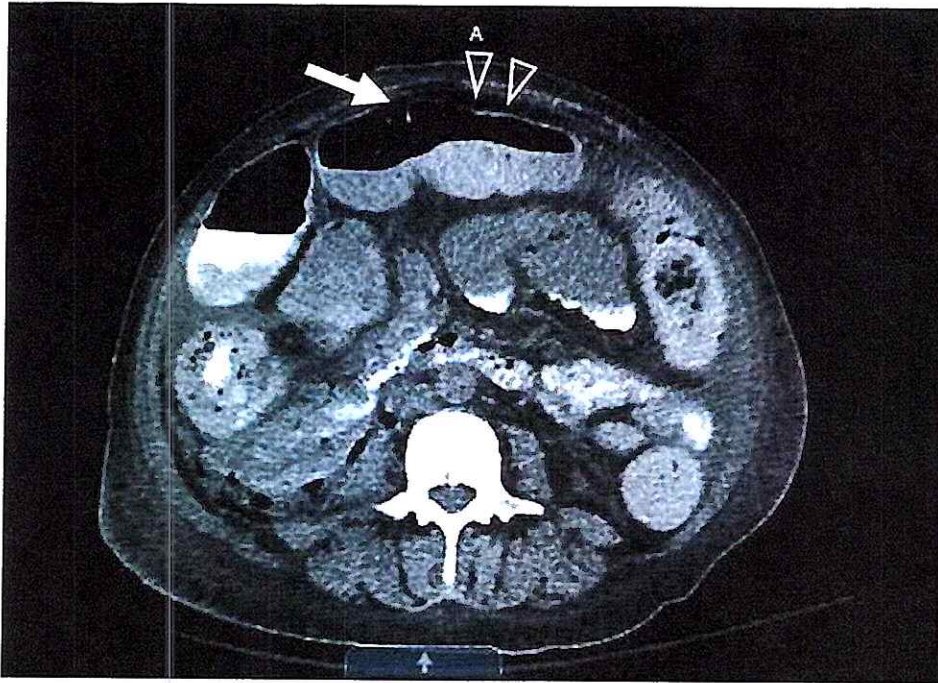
CT imaging showing transverse colon perforation (arrow) and pneumoperitoneum (arrowheads)
